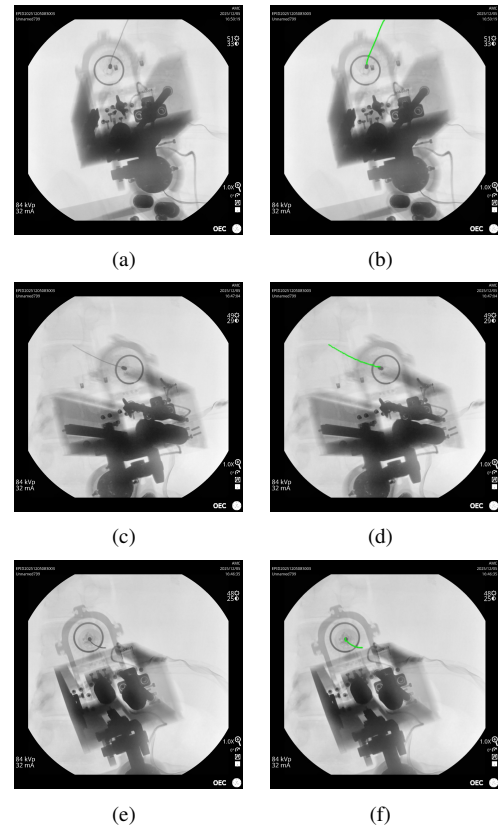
Comparison before and after Image Processing in Real X-ray image: (a),(c),(e) Before image processing with Real X-ray image, and (b),(d),(f) After image processing with Real X-ray image. The green line is the path of the found needle.
